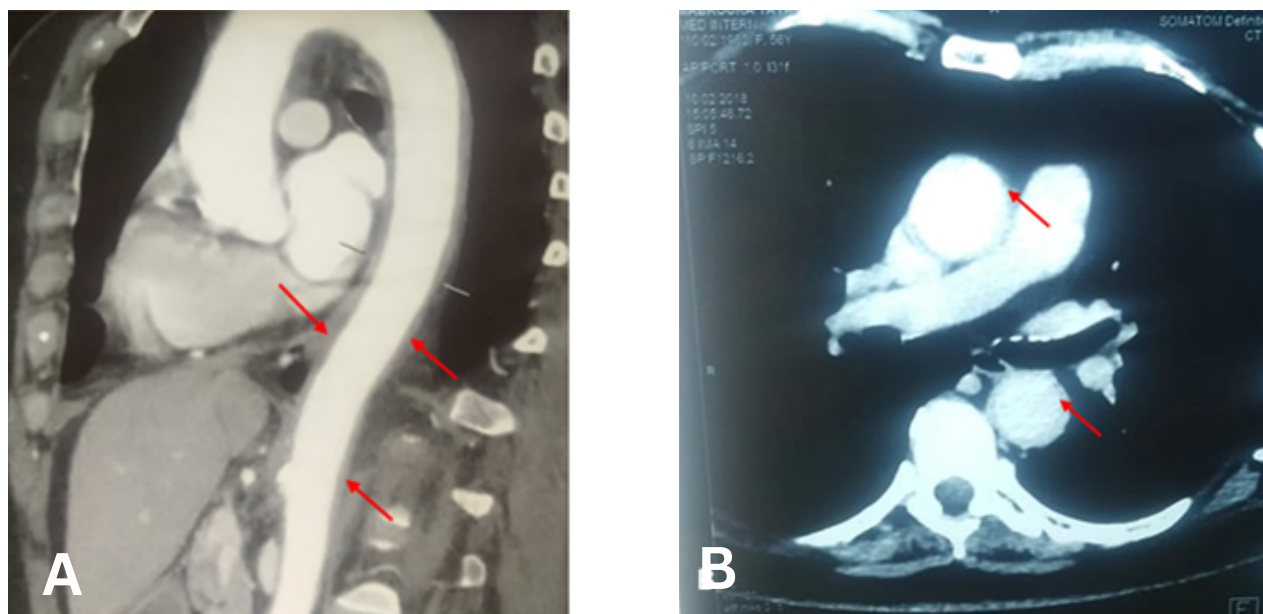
Thoracoabdominal angio CT
